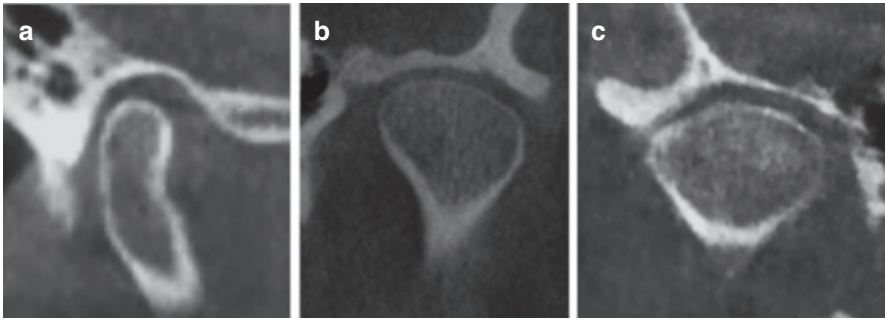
CBCT sagittal and coronal cross sections of TMJs in different patients show different condylar displacement patterns that may indicate disk displacement. (a) Posterior condylar displacement, (b) superior disk displacement, and (c) lateral superior disk displacement. The repositioning of the condyle in the fossa indicates that the soft tissues that usually inhabit that area that the condyle has displaced into are now not in their usual location. Disk displacement can only be verified clinically and through MRI evaluation
